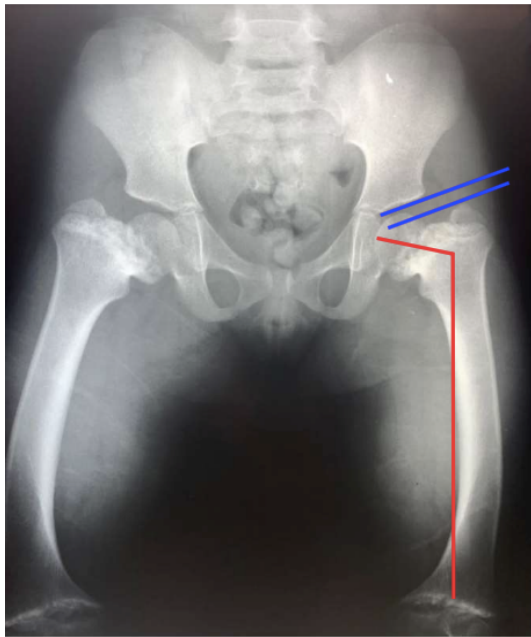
AP radiograph of pelvis and proximal femur in a known MCDS patient. The typical decreased neck-shaft angle (coxa vara) is seen (red). Furthermore, decreased articular distance (distance between tangential lines about the superior acetabular articular surface and superior pole of the greater trochanter) accompanies the coxa vara deformity (blue). Splaying and flaring of the growth plates is evident.
